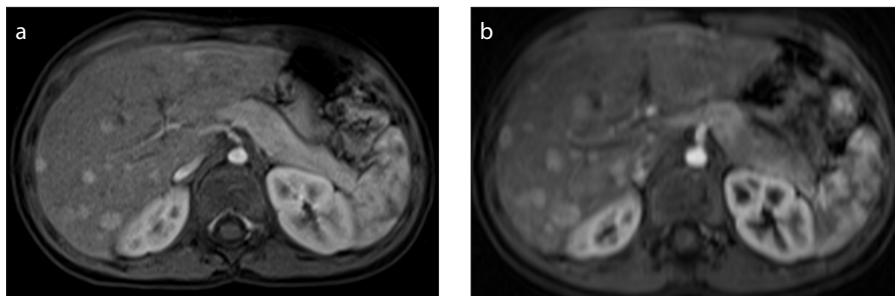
a, b. A 3-year-old boy with history of neuroblastoma. Gadoxetate disodium-enhanced MRI (a) shows strong arterial enhancement in the nodules on arterial phase. Gadoxetate disodium-enhanced MRI performed 12 months later (b) reveals growth of the lesions on the arterial phase.
